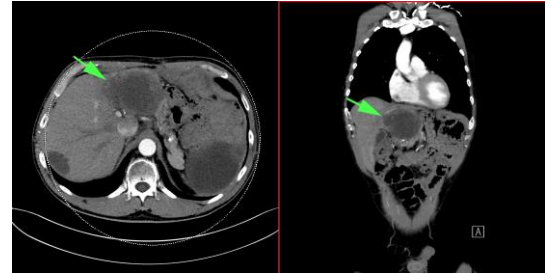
CT thorax and abdominal acquisition. The GIST tumor shows lower HU-values which is visible as a darkening region (largest evaluated tumor indicated by arrow). Axial and coronal slices are shown.
